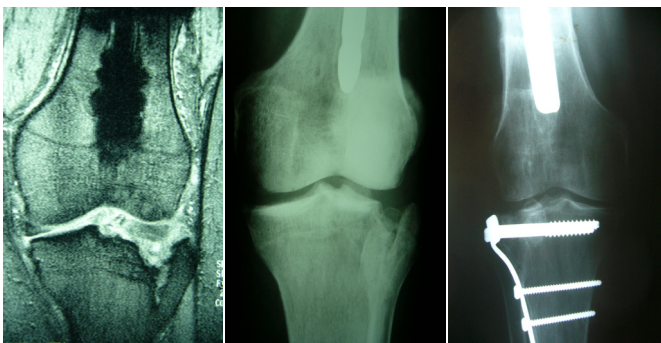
Patient with diaphyseal femoral fracture after a traffic accident. Six months later, after complaining from chronic knee pain, MRI of the ipsilateral knee was performed showing a fracture of the lateral tibial plateau (A). The fracture was treated with open reduction and internal fixation, with a satisfactory result (B, C: preoperative and postoperative x-rays).
